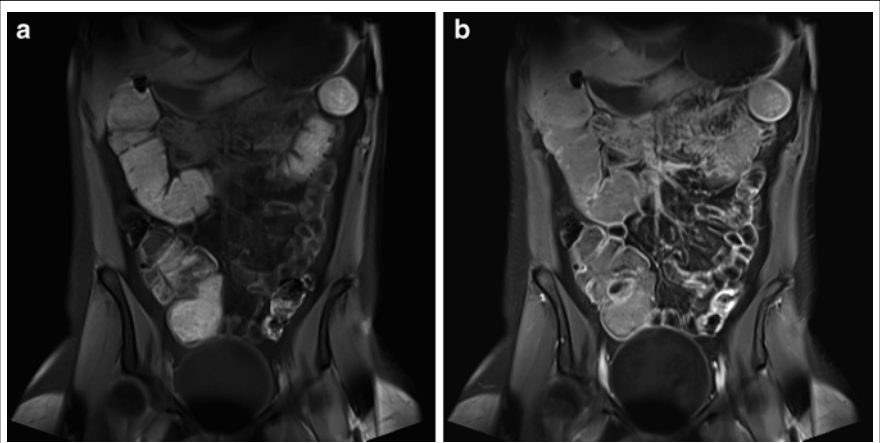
MRI ENTEROGRAPHY
